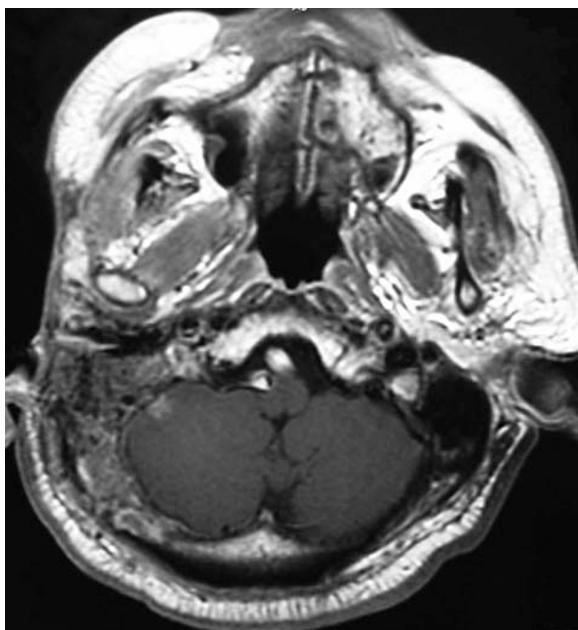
T1-weighted MR image with gadolinium enhancement three months after transarterial chemotherapy using the port system showing a disappearance of the lesion.
